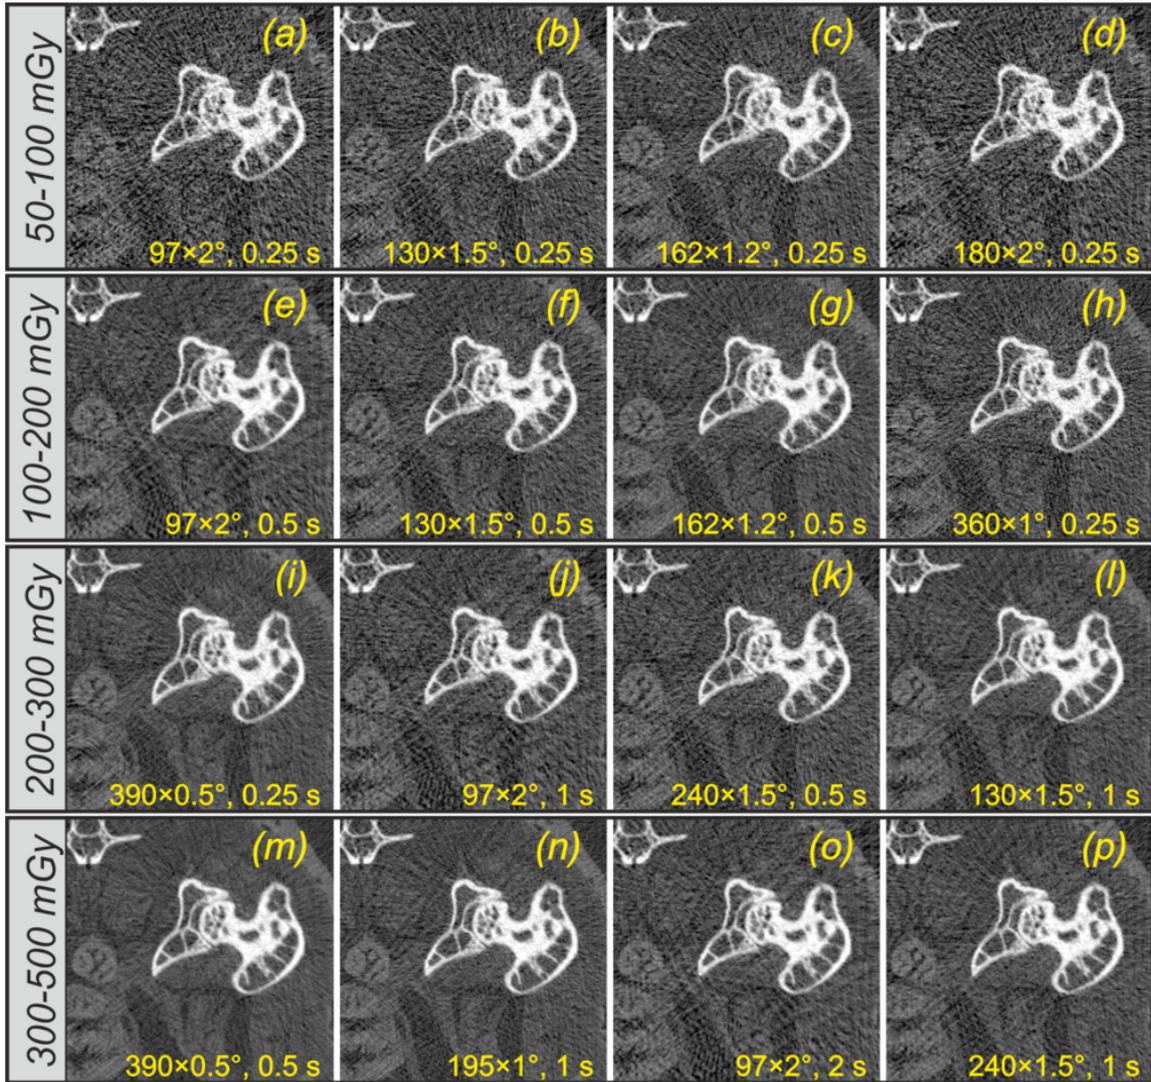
ROIs of a set of CT reconstructions acquired with absorbed dose within an interval of 50–500 mGy sorted in ascending order. The note at each image denotes “number of projections × angular step, acquisition time per projection”. The noise level decreases with dose increase as can be expected. On top of that, the detail detectability within a “dose category” improves with reduction of the angle step.
